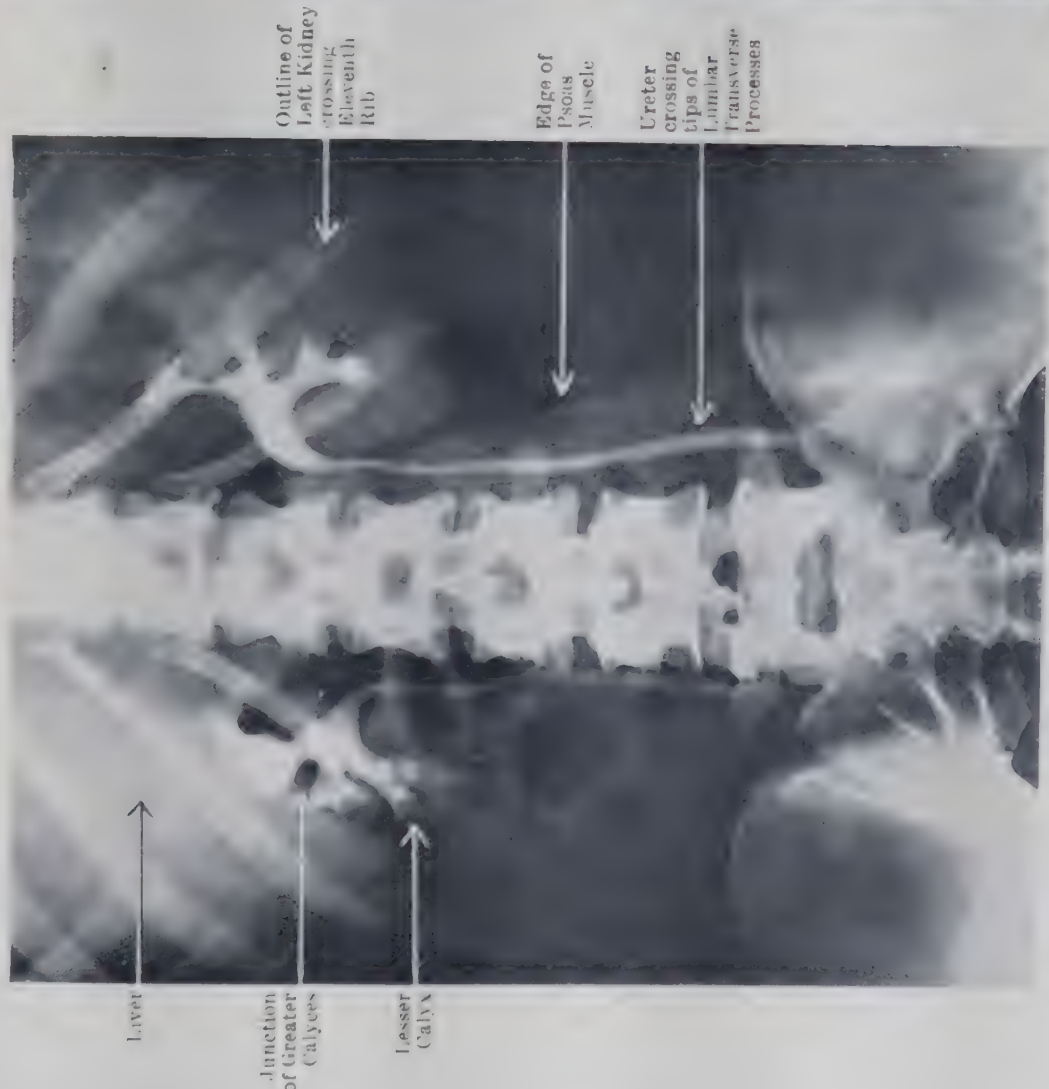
POSTERIOR RADIOGRAPH OF KIDNEYS AND URETERS (DESCENDING PYELOGRAPH) OF YOUNG WOMAN AGED 17.
